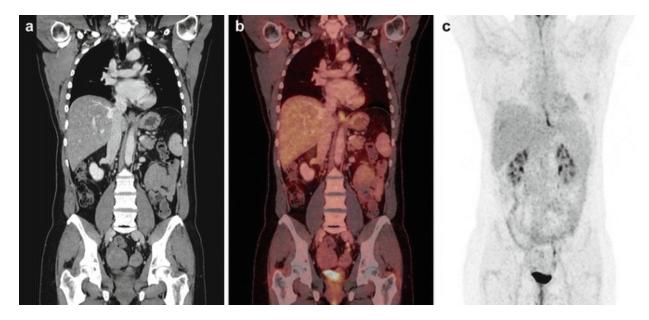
45 year old female patient undergoing PET/CT suffering from an adenomatous cancer with unknown primary after six cycles of chemotherapy. Contrast enhanced CT (\mathbf{a}), fused PET/CT (\mathbf{b}) and PET images (\mathbf{c}) are displayed. Increased functional uptake of the gastroesophageal junction can be observed. A mild reflux esophagitis was discovered during endoscopy
